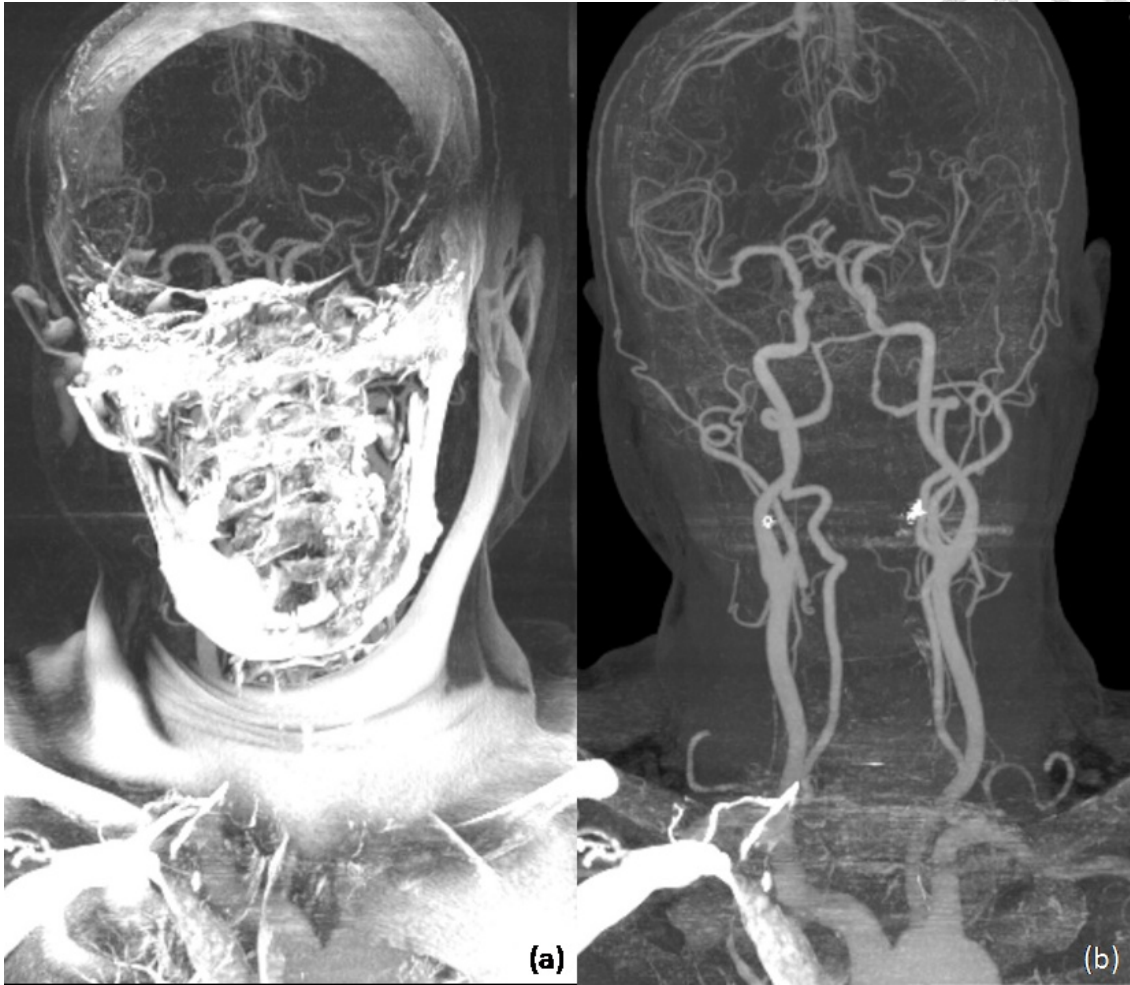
Thick maximal intensity projection (MIP) of subtraction CTA (a) without bone registration (b) with bone registration. The image quality improves after bone registration.
